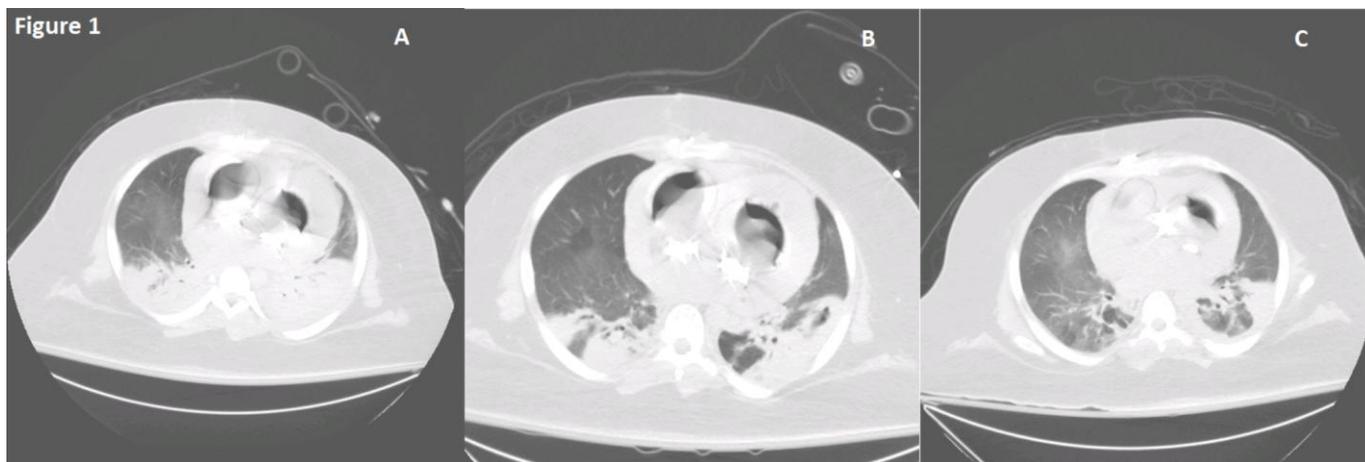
CT scan prior to prone positioning shows bilateral pneumonias (A). CT scan after completion of 5 day course of prone positioning shows interval improvement of pneumonia (B). CT scan 19 days after completion of prone positioning shows resolution of pneumonia.
